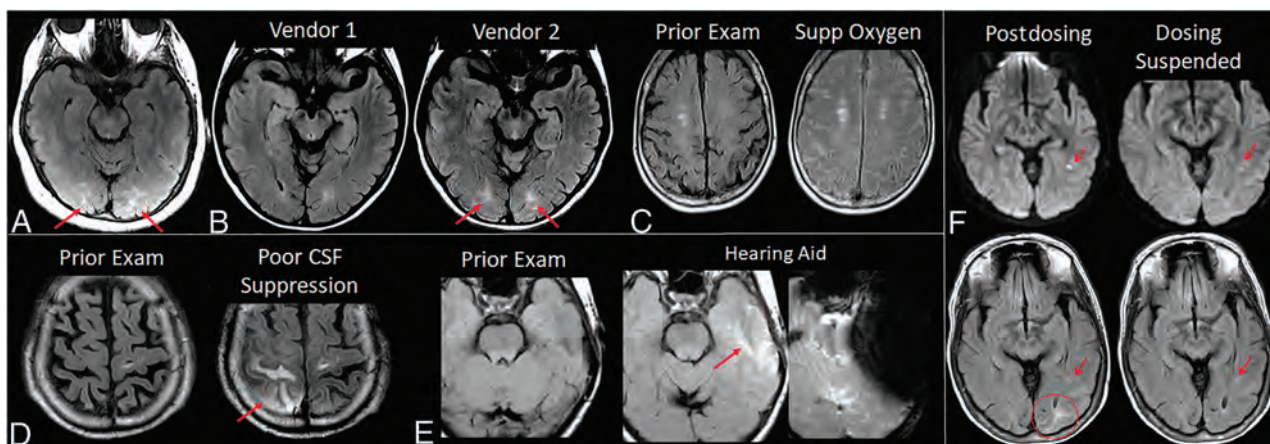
ARIA-E interpretation pitfalls and mimics. A, Shading artifacts with prescan normalize inadvertently turned off, results in T2-FLAIR hyperintense signal in the bilateral occipital white matter (red arrows) that mimics ARIA-E (edema). B, Axial T2-FLAIR images from 2 time points with the 2 scans performed on different vendors. T2-FLAIR hyperintense signal in the bilateral occipital white matter on vendor 2 (red arrows) appears to be new from the prior examination on vendor 1 and may be mistaken for subtle ARIA-E. The participant returned for repeat imaging on vendor 1, and the apparent abnormality was resolved (not shown). C, Diffuse sulcal T2-FLAIR hyperintense signal with administration of supplemental oxygen mimics ARIA-E effusion. The abnormality resolved on repeat imaging without supplemental oxygen. D, Poor CSF suppression results in artifactual sulcal T2-FLAIR hyperintense signal mimicking ARIA-E (red arrow) and was confirmed to be artifacts by resolution on immediate repeat imaging with optimized parameters. E, Susceptibility artifacts from a hearing aid results in apparent T2-FLAIR hyperintense signal (red arrow), new from the prior examination on which the patient's hearing aid was not in place. The third image in this set is the GRE scan showing the marked signal void artifacts from the hearing aid. The resulting susceptibility effect results in incomplete water suppression on T2-FLAIR, and the resulting artifacts mimic ARIA-E. F, Patient with left occipital subcortical T2-FLAIR hyperintense signal on the postdosing monitoring examination (mild ARIA-E, circle), which resolved on the follow-up monitoring scan. Separate subcentimeter focus of periventricular T2 signal with associated diffusion restriction (arrow, left) was consistent with an incidental acute/subacute infarct that showed expected evolution on the postdosing follow-up examination (right). Images courtesy of Biogen and the Dominantly Inherited Alzheimer Network. Supp indicates supplemental.
